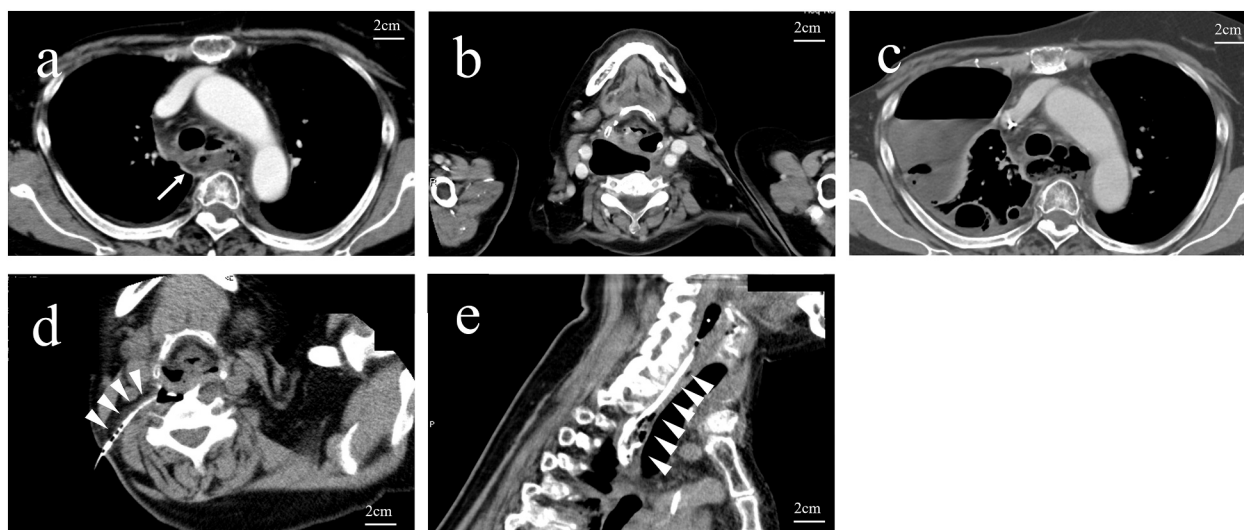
Computed tomography and mediastinal drainage.
